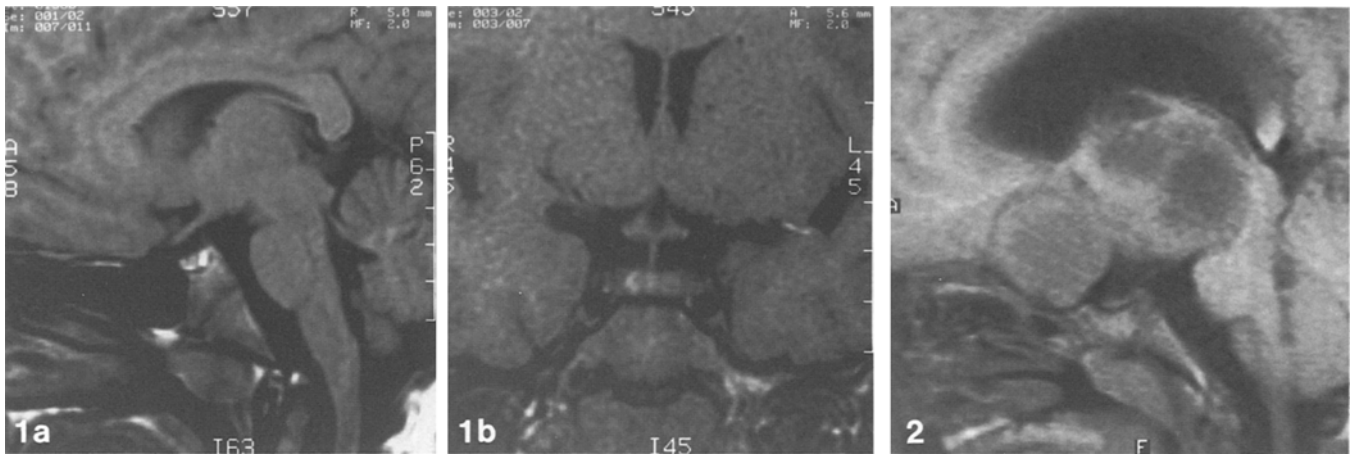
Sagittal (a) and coronal (b) spin-echo (SE 600/20) MR images of the pituitary in an 8-year-old girl with precocious puberty. The gland shows both the anterior (isointense with pons) and posterior lobes (bright spot) with a flat upper surface (grade 3)
